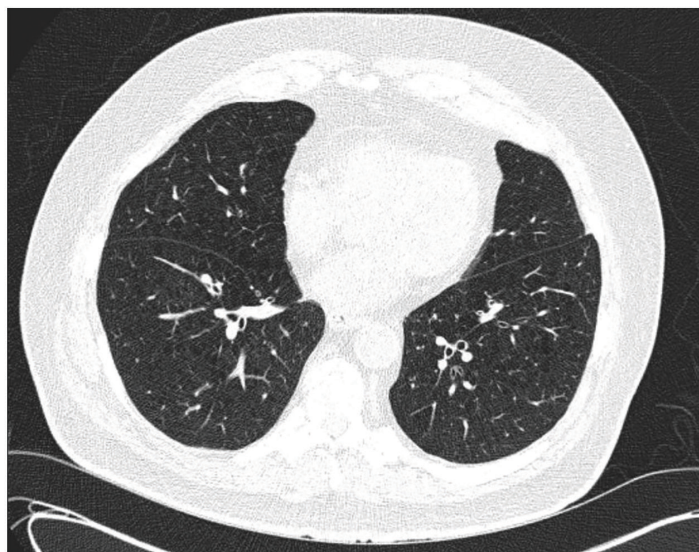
Axial Images of the CT Scan of the Chest Showing Upper Lobe Emphysema
